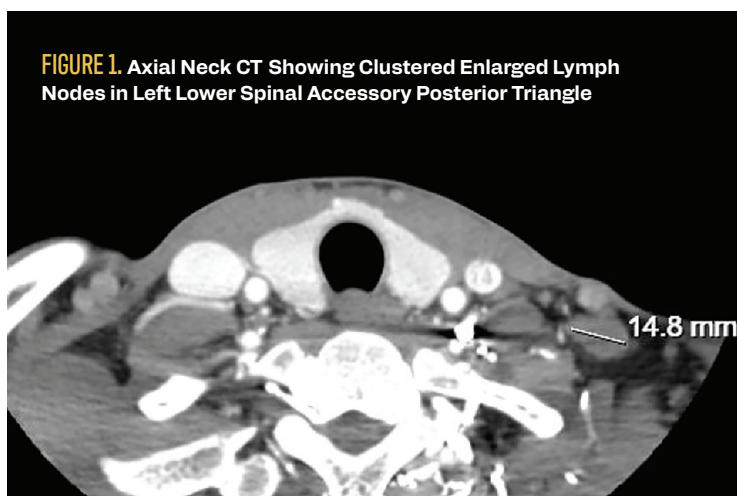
Axial Neck CT Showing Clustered Enlarged Lymph Nodes in Left Lower Spinal Accessory Posterior Triangle
